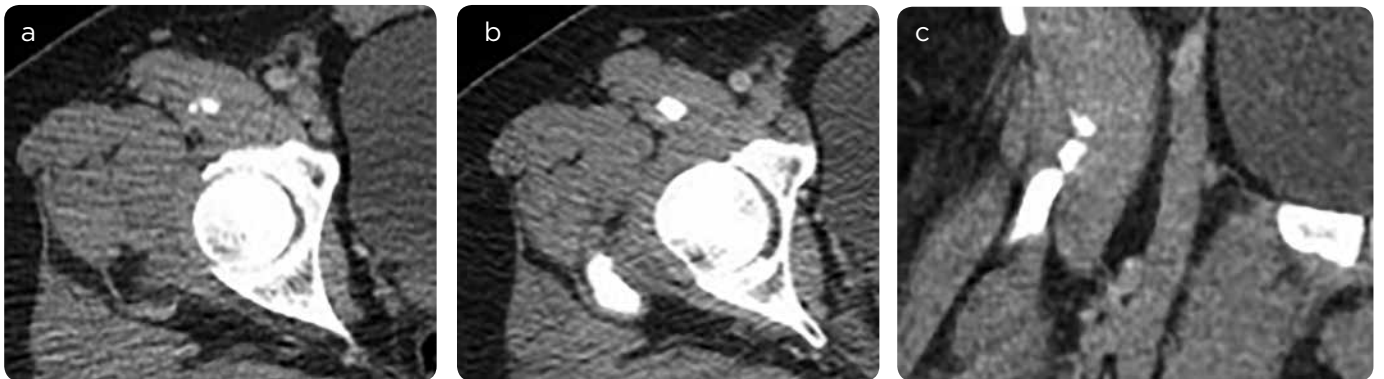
a and b) Axial cuts, c) Coronal cut of CT scan of abdomen at right hip height. In the anterior soft tissues of the right hip, a linear calcified image with phalanx morphology corresponding to pelvic finger is observed.
